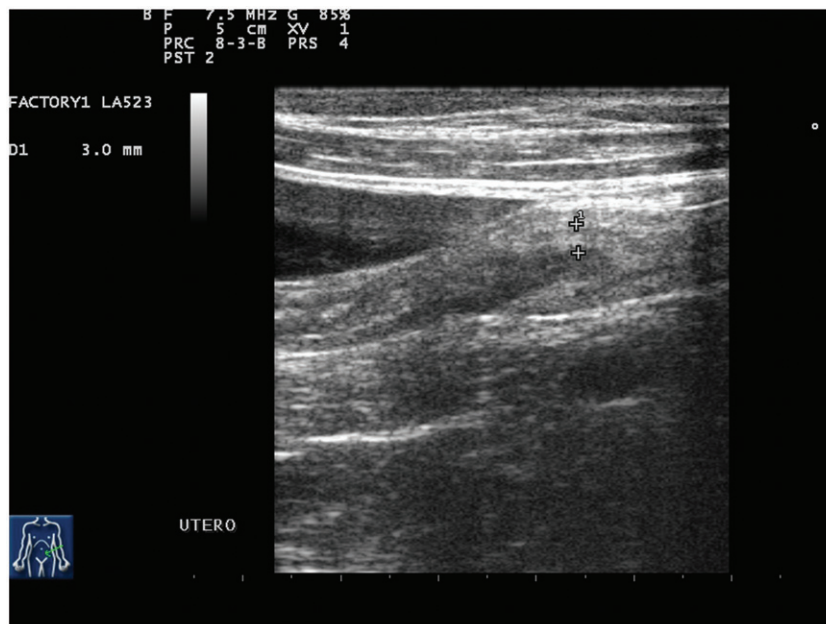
Ultrasonographic examination on day 14 (dorsal recumbency, 7.5 MHz multi-frequency linear probe array): reduction of the thickness of the endometrial layer of the uterine wall (maximum thickness 3 mm) and the absence of cystic intra-wall structures.
